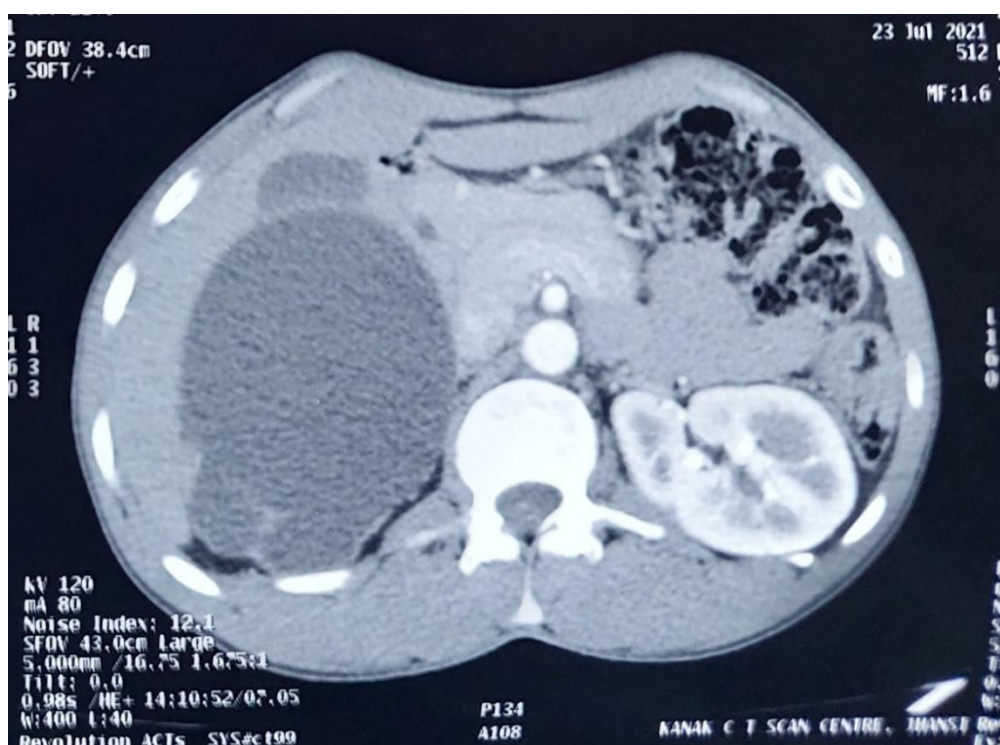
Transverse section of CT Urography showing a well defined cystic lesion 8x7.7x10cm in size in right kidney
